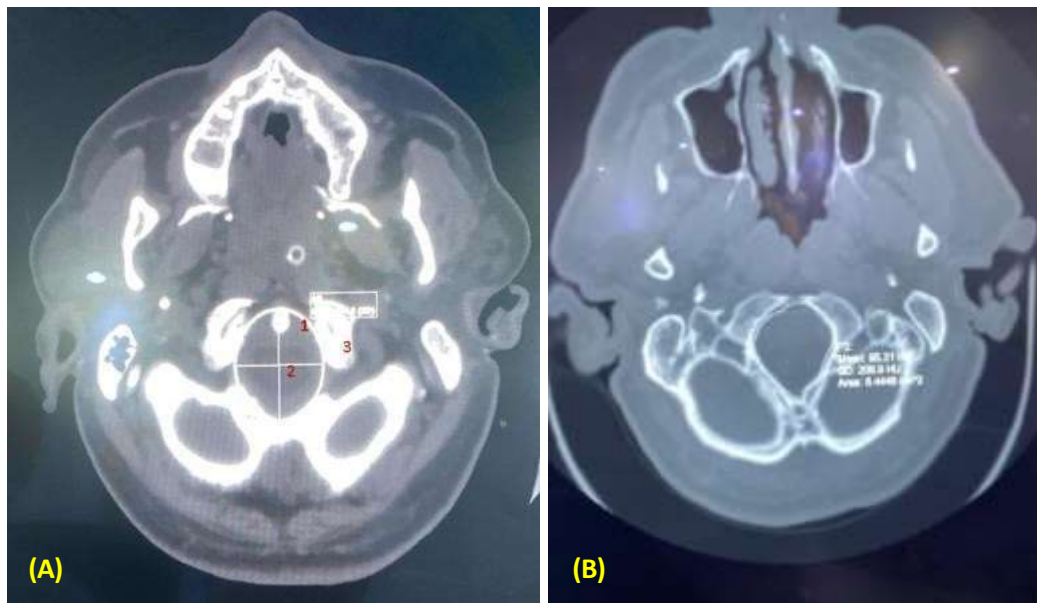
Image showing 3D multiplanar reformation on CT console with reformation lines oriented along lower most points of basion and opisthion (sagittal plane) and the mid-point of cervical spinal canal at C1/C2 level (coronal plane) to get the maximum cross-sectional area of foramen magnum
